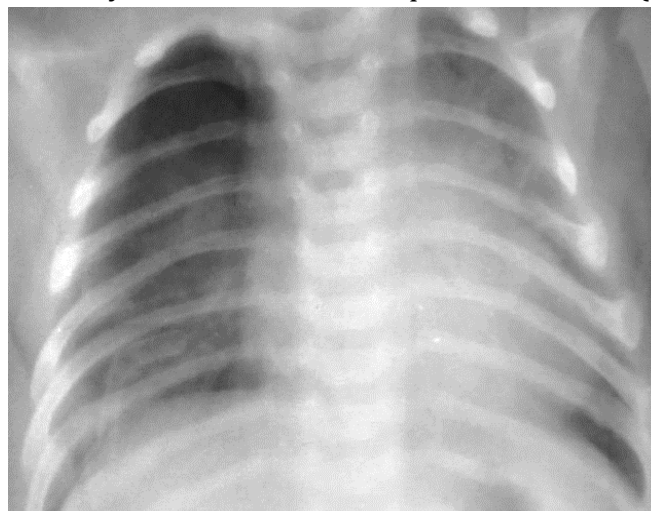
Patient Z., 2 years 7 months, medical record number 6231-1189. Post-lobectomy status with partial atypical resection for right CCAM. Plain chest radiograph - marked emphysematous distension of the remaining lung.
